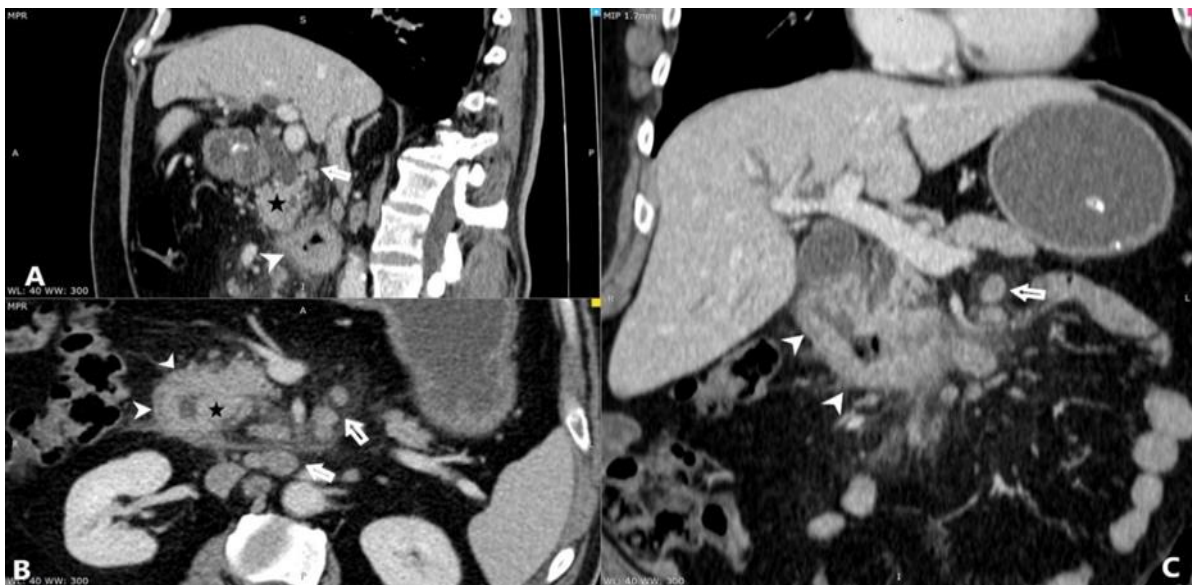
CECT of the abdomen, venous phase: sagittal (A), axial (B), coronal (C) views, showing duodenal wall thickening both above and beyond papilla (white arrowheads) with nodular aspect at para-ampullary level (*); biliary tree is mildly dilated; adenopathies (arrows) and fat stranding around them as well as peri-duodenal are also present. *CECT: Contrast-enhanced computed tomography*
